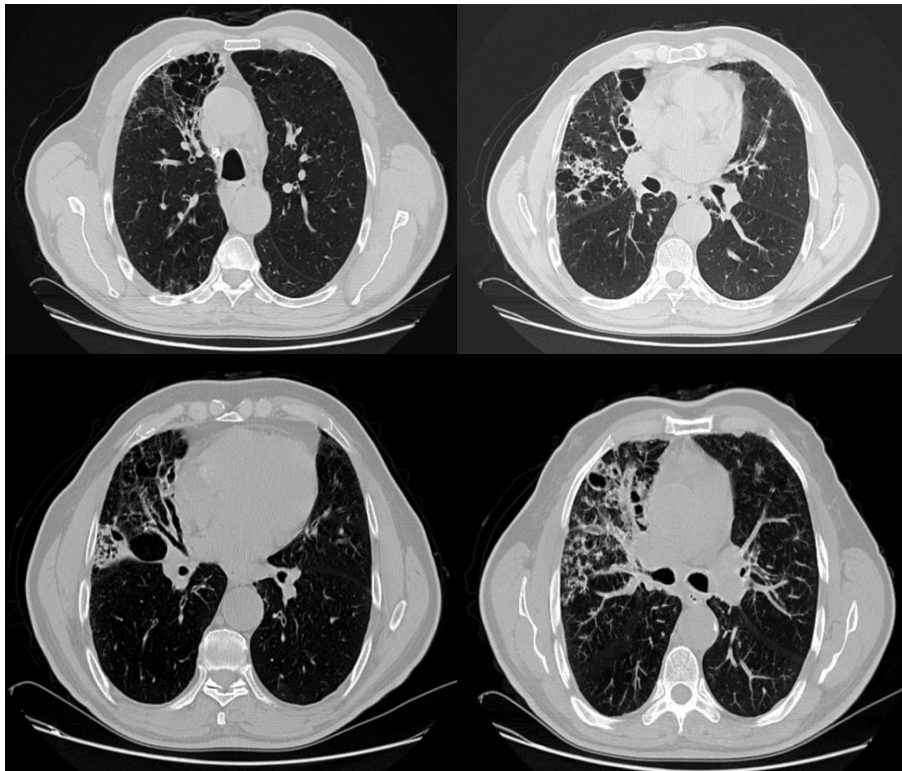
A 56-year-old patient presented with exertional dyspnea. A non-contrast chest CT scan, axial slices; parenchymal window: bilateral apical ground-glass opacities. Septal and non-septal thickening with bronchial distortion, some honeycombing, and traction bronchiectasis predominantly affecting the right middle and lower lobes. Bronchial wall thickening predominantly in the basal lobes with branching micronodules confluent in some areas. Diagnosis: Idiopathic non-insulin-dependent pneumothorax (NIP).
